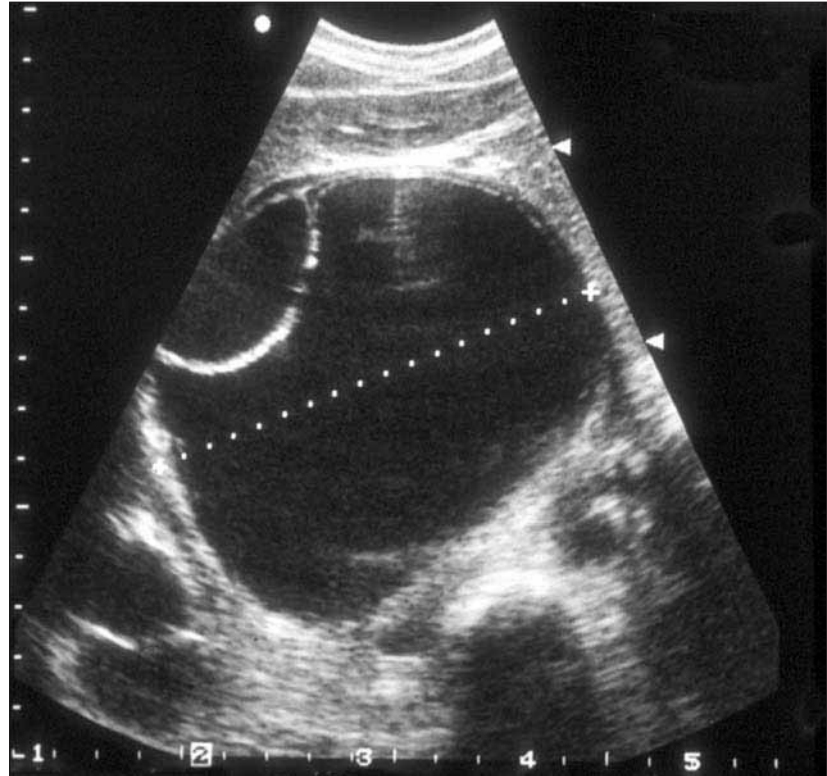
Ultrasound showing a univesicular cyst with a “double membrane” and one daughter cyst.
